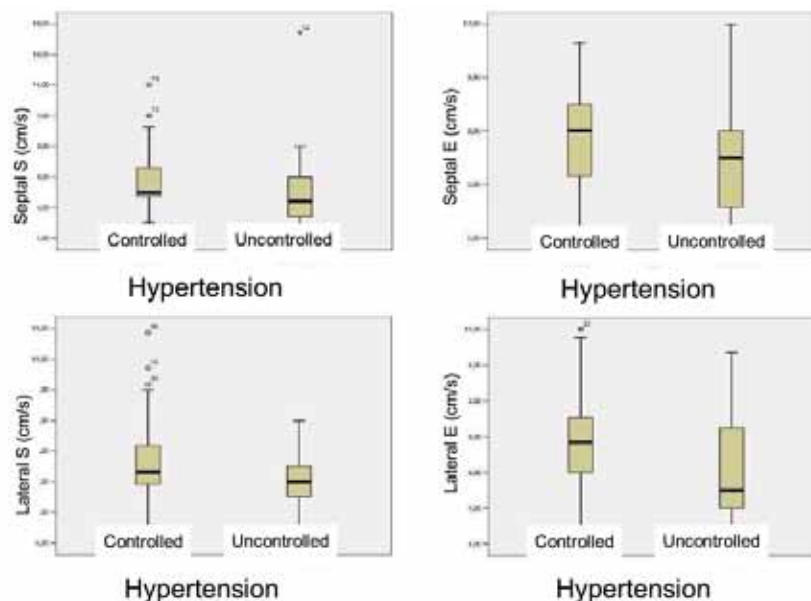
Tissue Doppler parameters that differ significantly between the groups: septal Sm and Em, and lateral Sm and Em.
